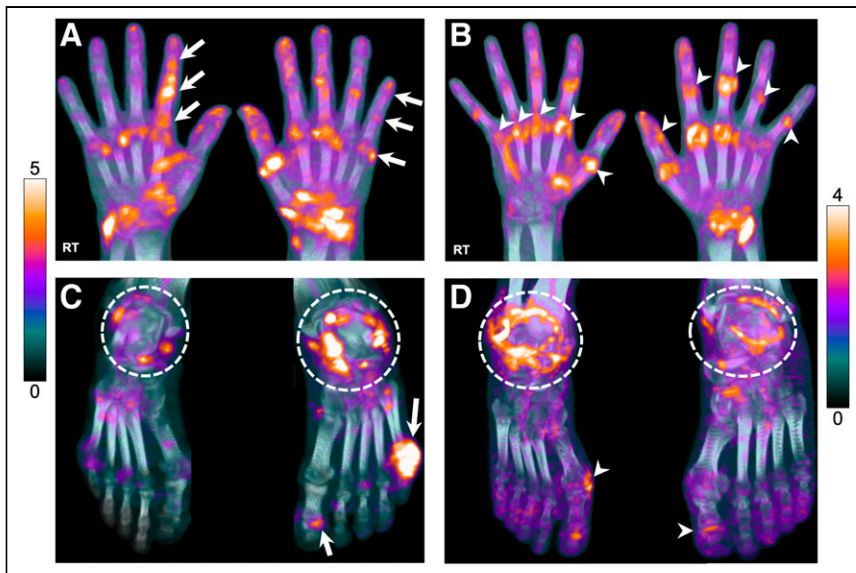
^{18}F -FDG uptake in hands and feet of participants with AIA. (A) A 54-y-old man with PsA showing elevated uptake at multiple hand joints. Raylike distribution, as indicated by arrows, in metacarpophalangeal (MCP), proximal interphalangeal (PIP), and distal interphalangeal (DIP) joints in sequence, attributed to involvement of flexor or extensor tendons. (B) A 47-y-old woman with RA, showing involvement of entire row of MCP (arrowheads, right hand) and PIP/interphalangeal (IP) joints (arrowheads, left hand). (C) Feet images of same PsA participant in A, demonstrating increased uptake at ankle joints (dashed circles), more intense on the left side, and left first IP and fifth metatarsophalangeal (MTP) joints (arrows). (D) Feet images of a 71-y-old man with RA, demonstrating bilateral, rather symmetric, uptake around ankles as well as right first MTP and left first IP joints, suggestive of synovitis (arrowheads).
